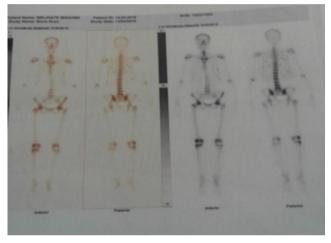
Whole-body bone scintigraphy before the treatment with characteristic chest and knees bone looser zones
